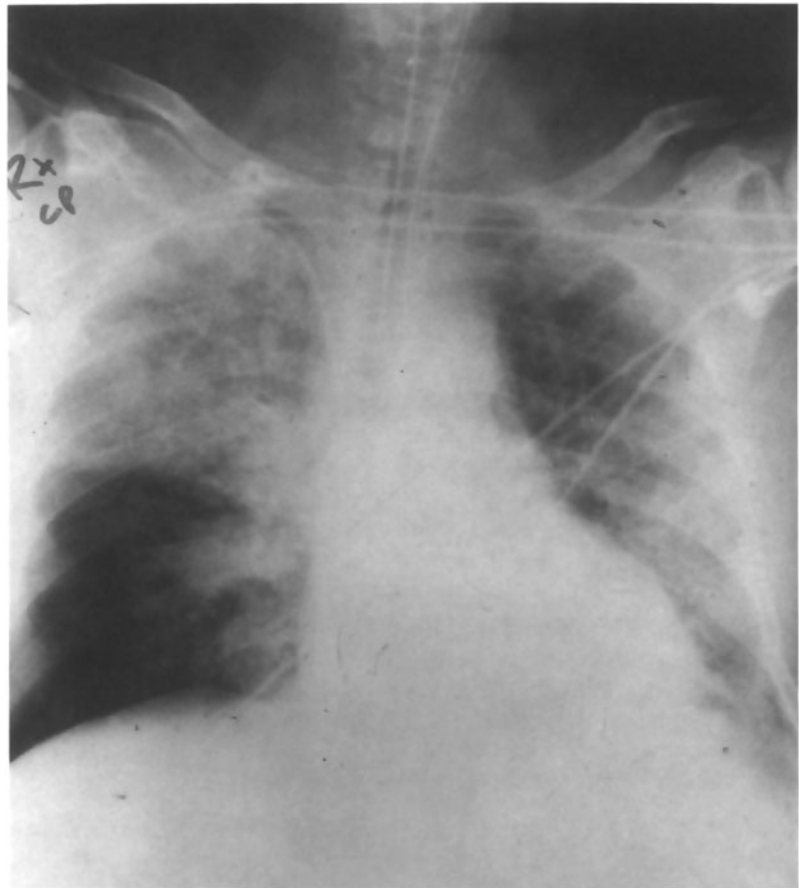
Chest radiograph of a patient with disseminated strongyloidiasis. The patient had fever, hemoptysis, hypoxemia, and gram-negative bacteremia with fluctuating, dense pulmonary infiltrates.
